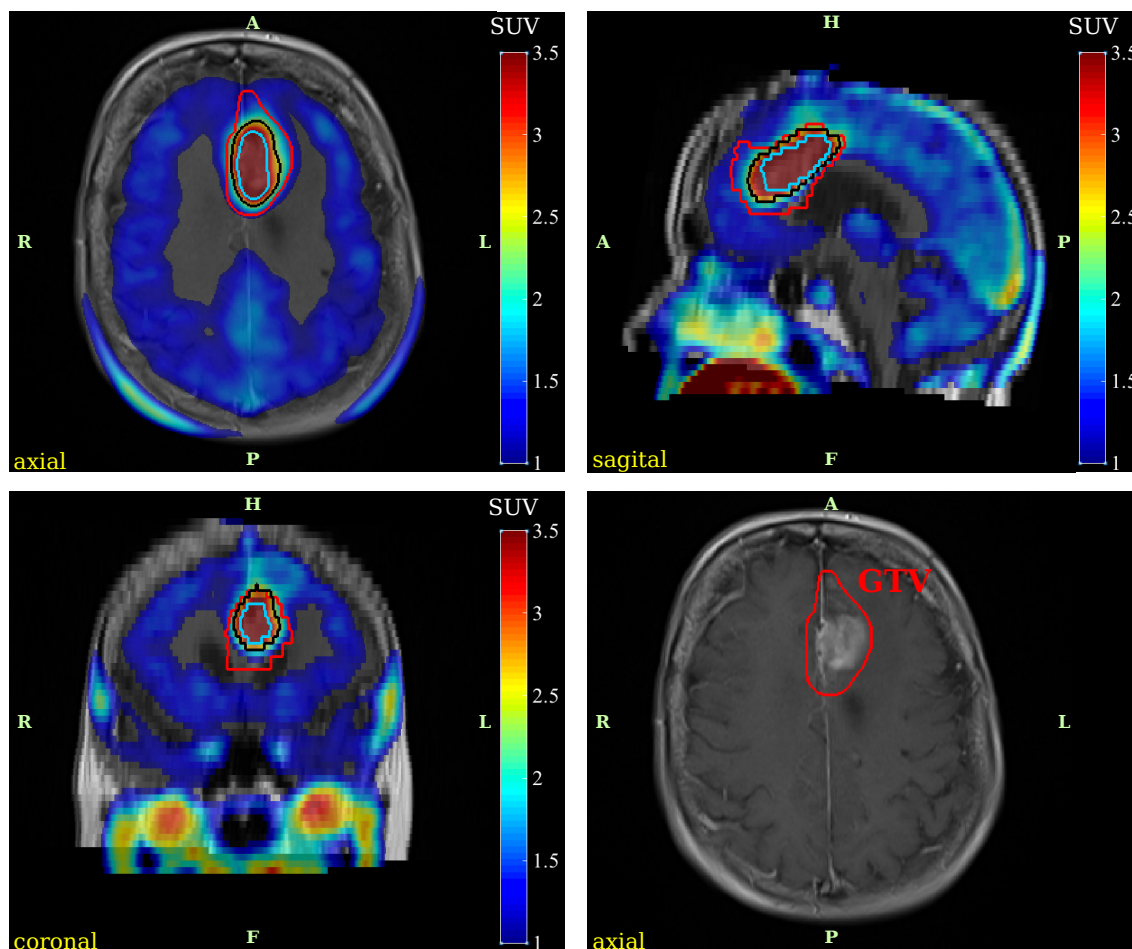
The MITK *SUV* calculation plugin allows for overlay of standard T_1 weighted contrast enhanced MRI (right bottom) with the *SUV* image (colored), calculated from ^{18}F -FET PET scans. Isocontours can be drawn on basis of the *SUV* image and compared to the radiotherapy planning contours. Here, the isocontour 50% (black contour) and 70% (light blue contour) are compared to the treatment planning GTV (red contour).
